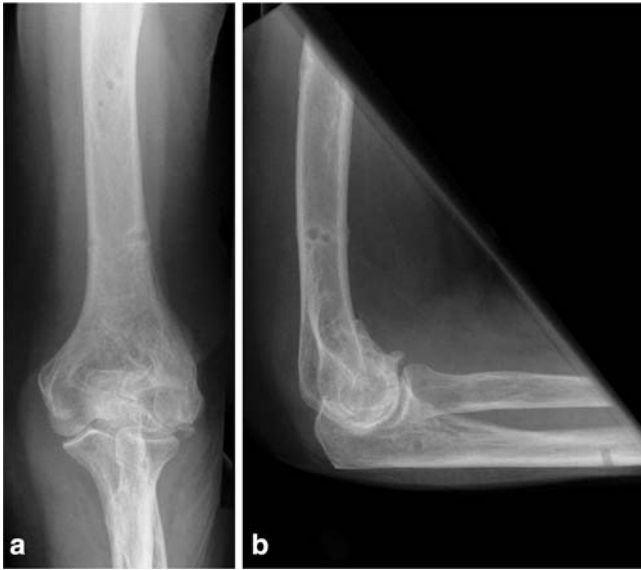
Anteroposterior (a) and lateral (b) radiographs made 4 weeks after hardware removal and 11 weeks after injury show a bony consolidated fracture of the elbow
